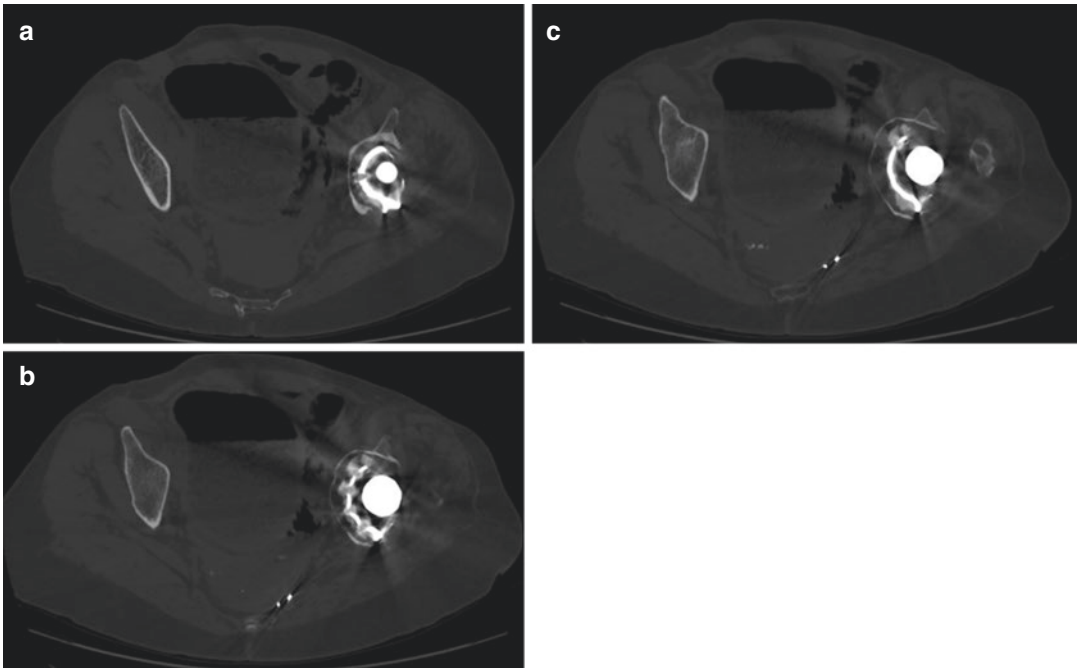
(a–c) Preoperative computed tomography (CT) further demonstrated extensive acetabular osteolysis with superolateral migration of the revision acetabular component
